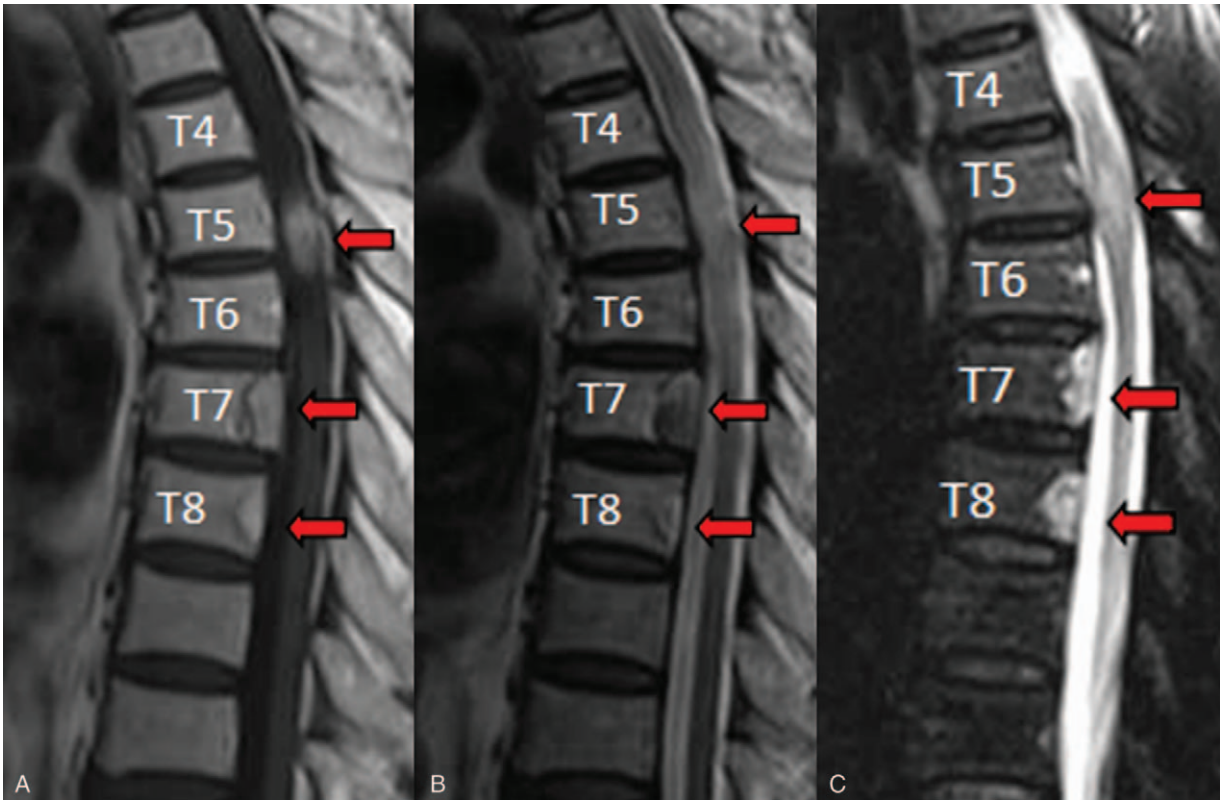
Serial preoperative magnetic resonance imaging. (A) T1-weighted imaging; (B) T2-weighted imaging; (C) Gd-DTPA contrast imaging) showed an intradural extramedullary tumor (red arrow) at the T5-6 levels and 2 intraosseous tumors at the T7-8 levels (red arrow).
